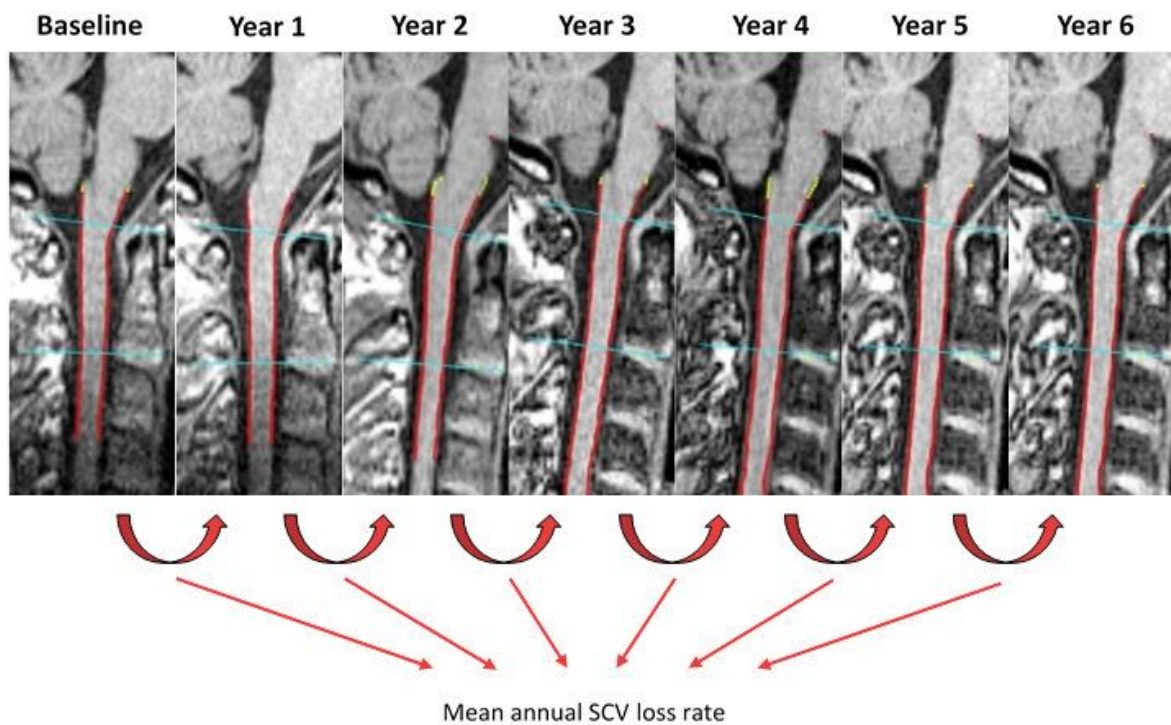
Figure e-2. Segmented MR images of one representative RRMS patient. The blue lines on each image depict the segmented volume, which corresponds to the upper cervical cord between the foramen magnum and the C2/C3 intervertebral disc. The mean annual SCV loss rate for each patient was calculated using the subsequent SC volume values from a follow-up to the next.
